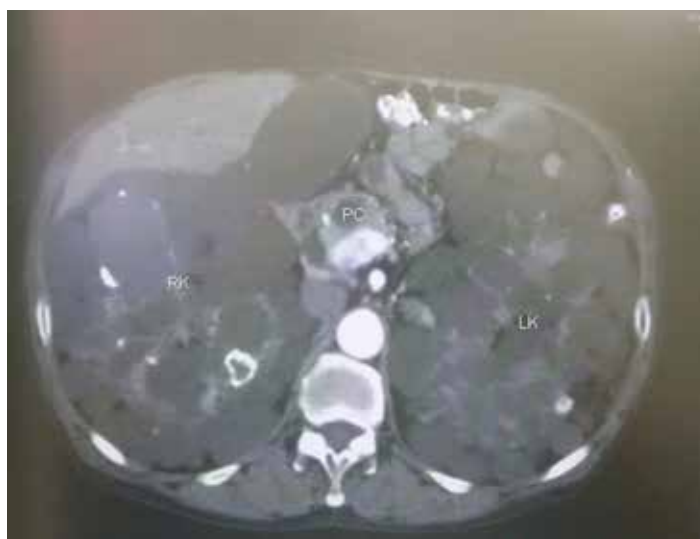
CT Scan shows small abdominal compartment due to enlarged bilateral polycystic kidneys (PC -pancreatic cyst; RK -right kidney; LK -left kidney)
